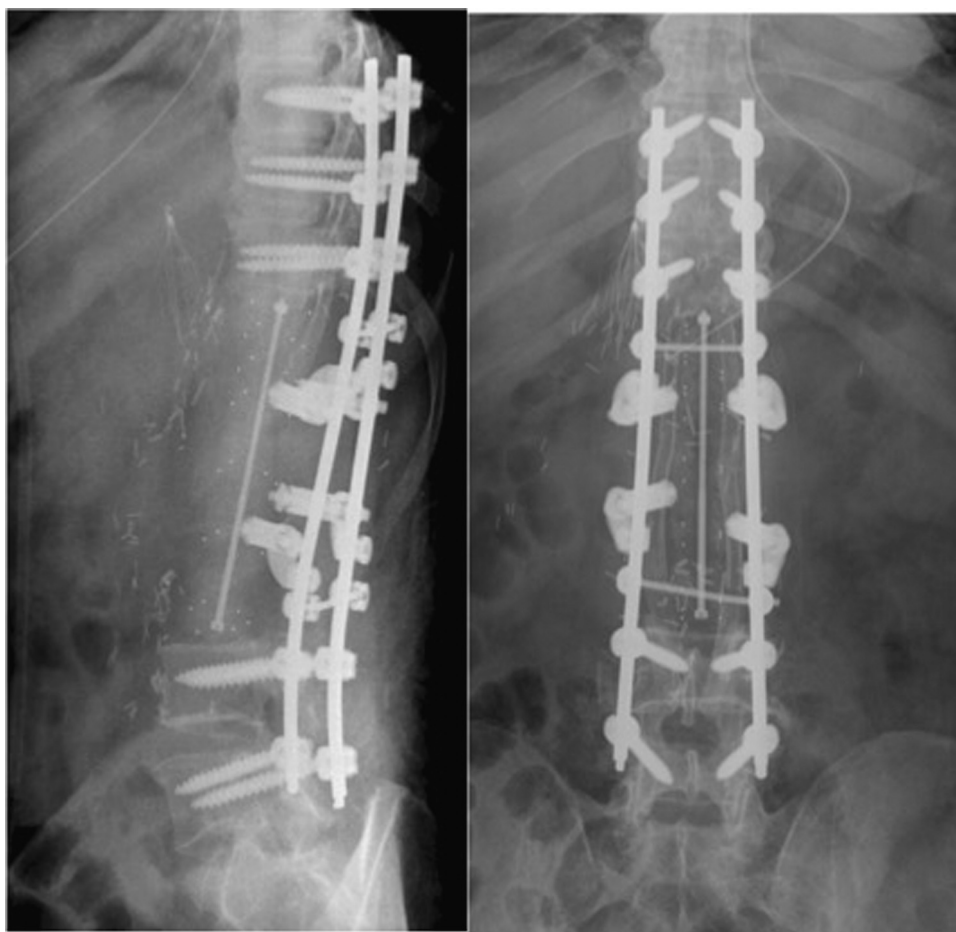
An anteroposterior radiograph and profile of the postoperative lumbar spine.
